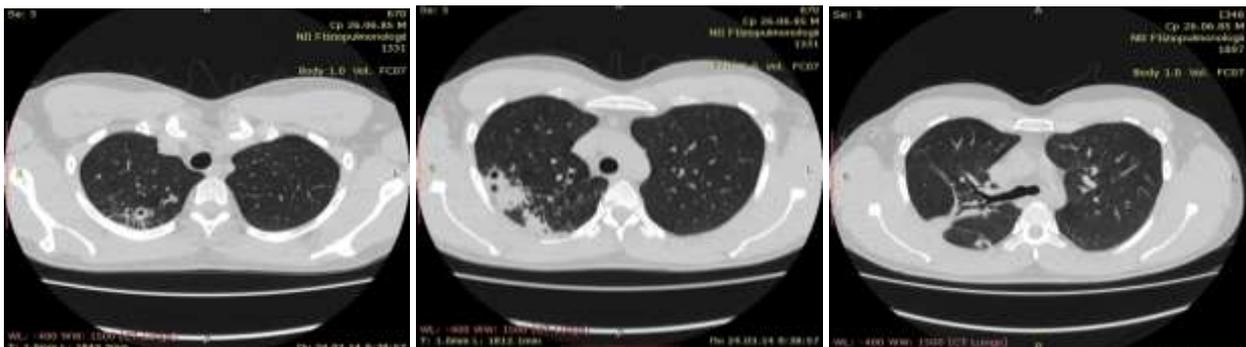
Patient G. CT of breast in 3 months of therapy
